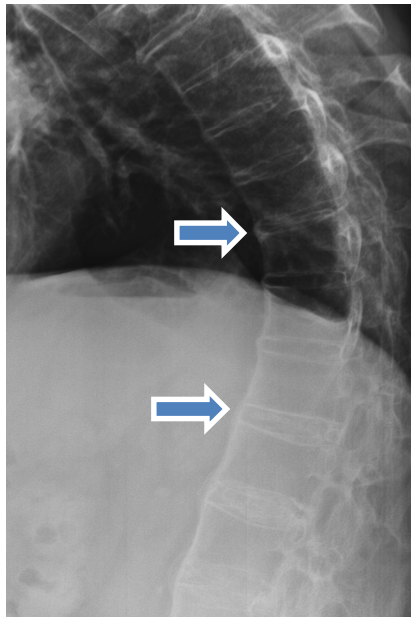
Lateral lower thoracic/upper lumbar radiograph demonstrating multiple levels of thin bridging syndesmophytes at anterior disc margins (arrows) and loss of the anterior concavity of the vertebral bodies (squared vertebrae).
